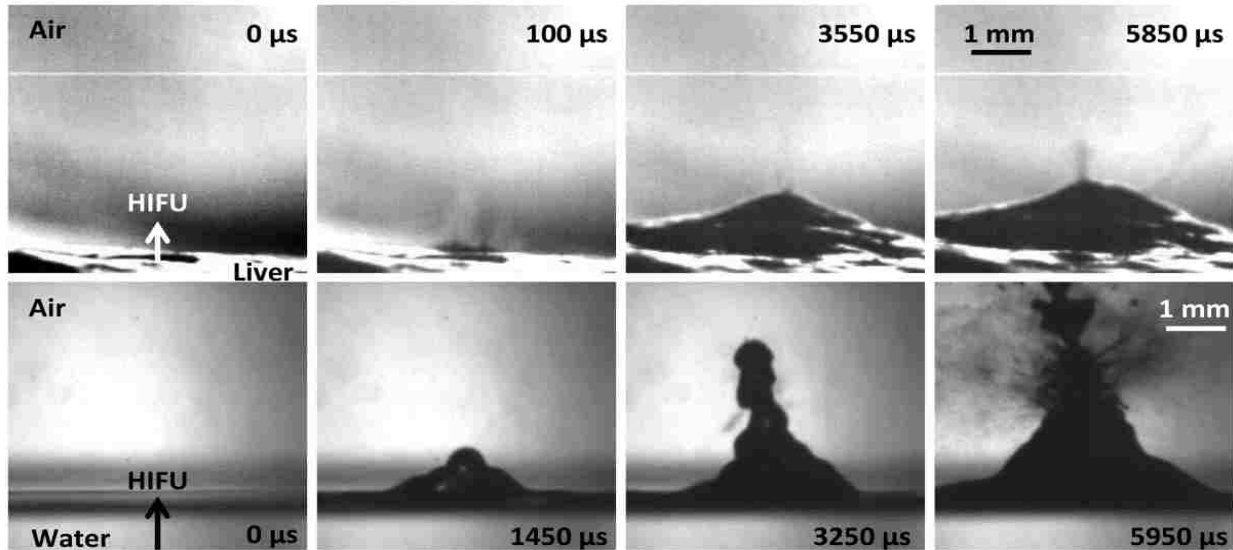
A direct comparison of liver (upper) and water (lower) at intensities slightly above their respective atomization thresholds (8100 W/cm^2 derated for liver and 550 W/cm^2 for water). In both cases, the first frame occurs $20 \mu\text{s}$ after the ultrasonic wave arrives at the interface. The second shows the initial spray of atomization in liver (upper) and the mound forming in water (lower) with no atomization. The third frame shows the small spray of atomization from the mound in liver and the first case of atomization for water; whereas the final frame shows atomization at its most significant. The timing is fairly similar between liver and water; the only difference is that liver has that initial spray of atomization before the mound forms and enhances atomization, while at this intensity water forms the mound before atomization occurs. In both cases, the total HIFU-on time was 10 ms.
